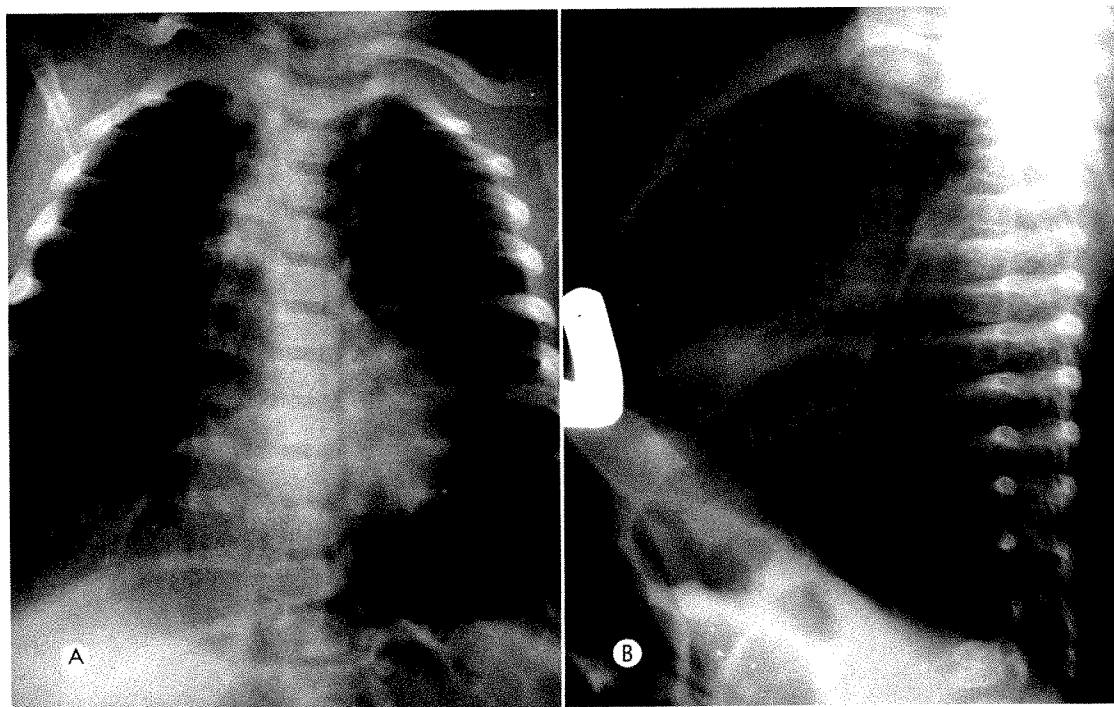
B.H., a 6 week old white female, was admitted for heart studies with cyanosis, weakness, and failure to thrive. Heart catheterization showed some increase in right-sided pressure but otherwise was normal. Oxygen, penicillin, streptomycin and digitalis therapy gave almost complete remission. (*A* and *B*) Roentgenograms show "snubbed off" arteries, high sternum, low diaphragm, collapse and consolidation with adjacent overaeration.
